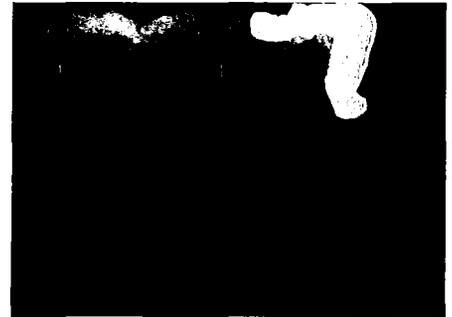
Case 3 preoperative radiograph. Tooth No. 18 with severe bone loss to the distal involving the periapical area
